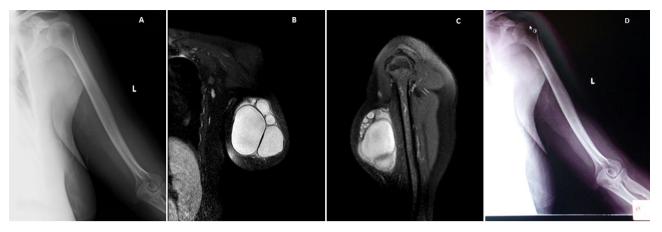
(A) Pre-operative X-ray, (B) coronal, (C) sagittal MR, and (D) Post-operative X-ray.
